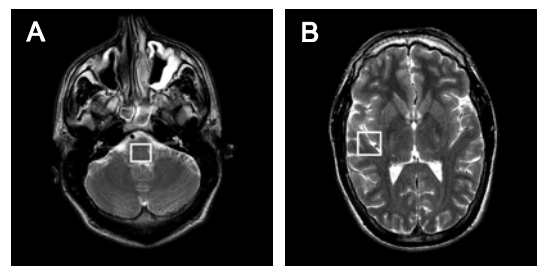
MR images of the brain showing the location of the regions of interest (ROIs, $2 \times 2 \times 2 \text{ cm}^3$) selected for the ^1H MRS experiments in the (A) pontobulbar region and (B) right temporal lobe.
